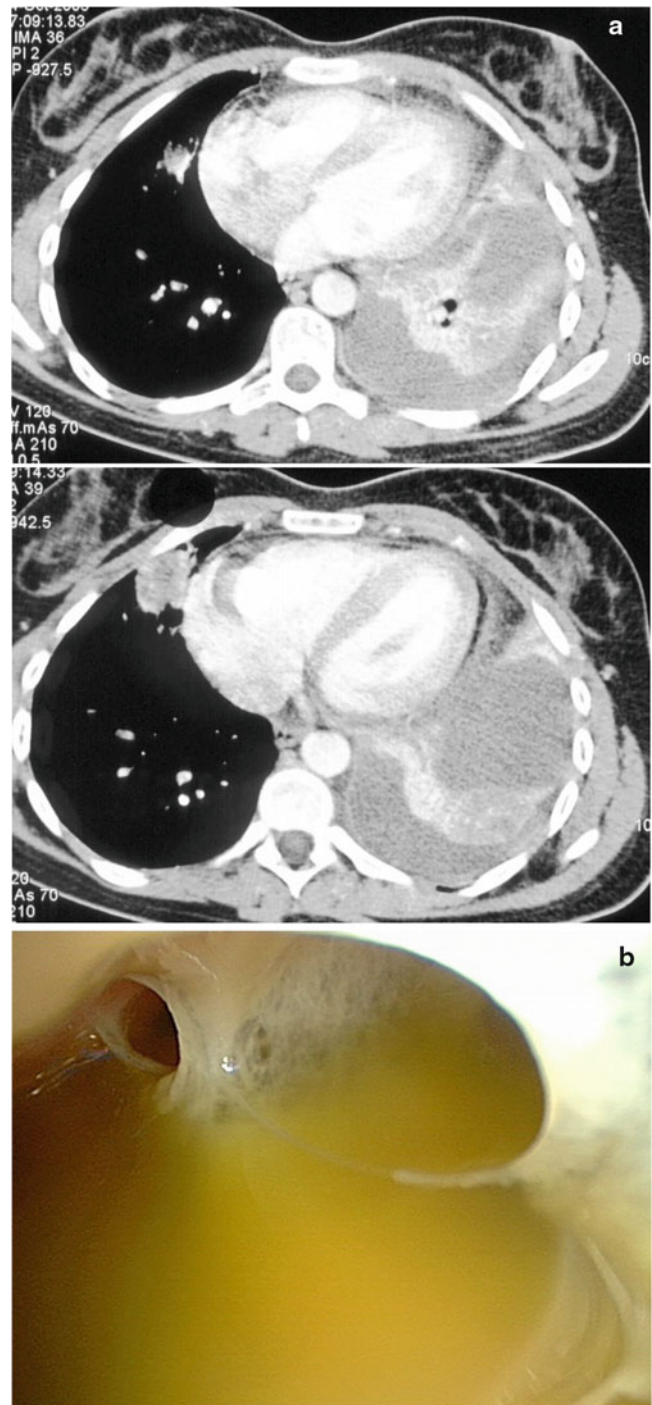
Complicated parapneumonic effusion. (a) Radiologic (CT) and (b) intraoperative appearance, respectively
